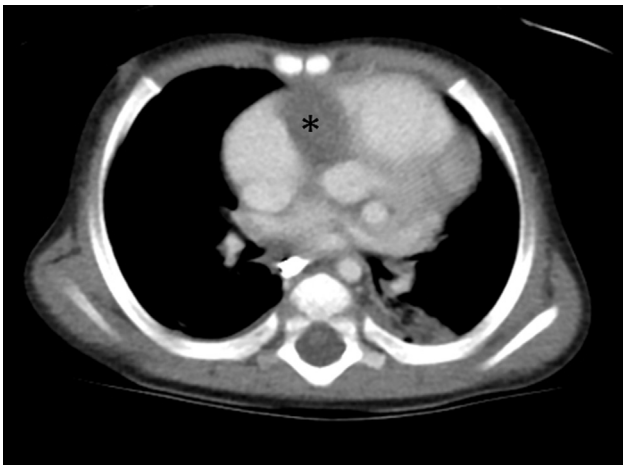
Computed tomography of the chest demonstrates a round focus of hypoattenuation (asterisk) present within the lateral aspect of the right AV groove extending superiorly and measuring 18 x 23 x 22 mm.
